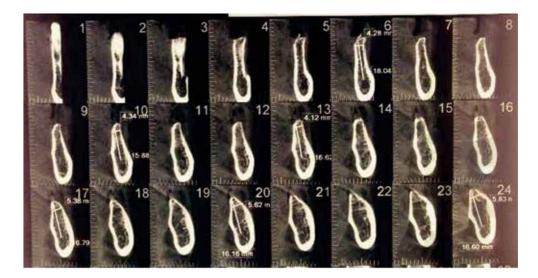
Radiographically, the corresponding area was extremely thin.
